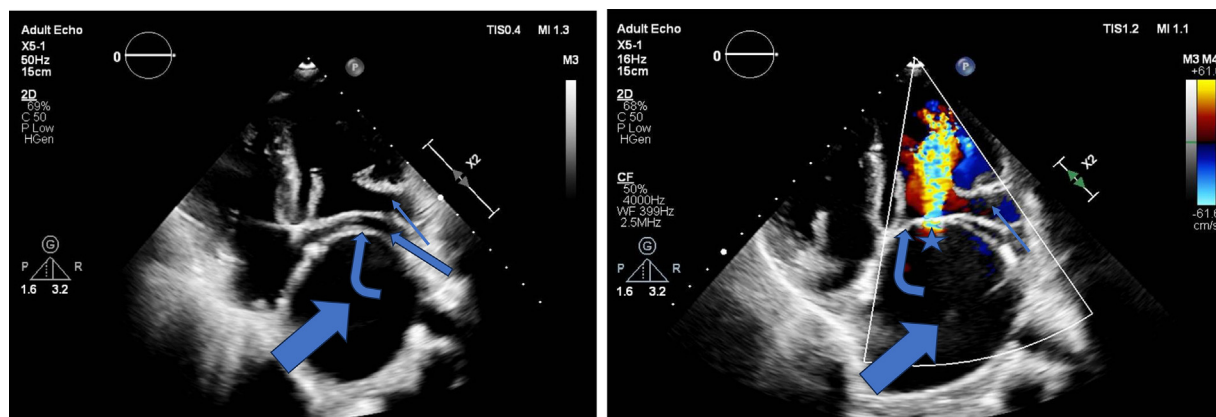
Transthoracic Echocardiography Apical 4 chambers view showing dilated coronary sinus (Arrow) and fibromuscular membrane (curved arrow) with internal fenestration and turbulent flow (star) dividing the left atrium into 2 chambers, a proximal chamber (thick arrow) containing the pulmonary vines, and a distal chamber “true” left atrium (thin arrow) containing the left atrial appendage.
